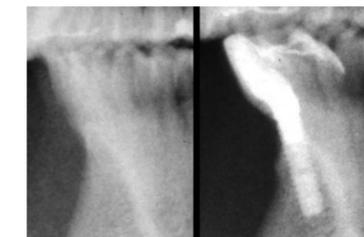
Cephalometric radiographs taken before and after implant therapy show a clearly visible additional amount of bone that was created at the buccal aspect of the implant.
